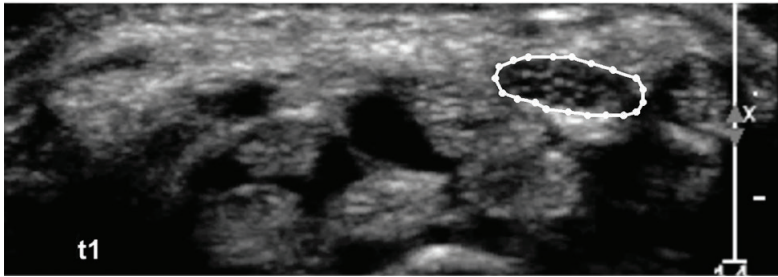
A transverse sonographic image at the carpal tunnel inlet of the right wrist of a healthy person during extension of all fingers. A manually placed polygon on the outside border of the median nerve is displayed. These polygons were also placed manually around the median nerve and flexor tendons in the different frames of the cines.
